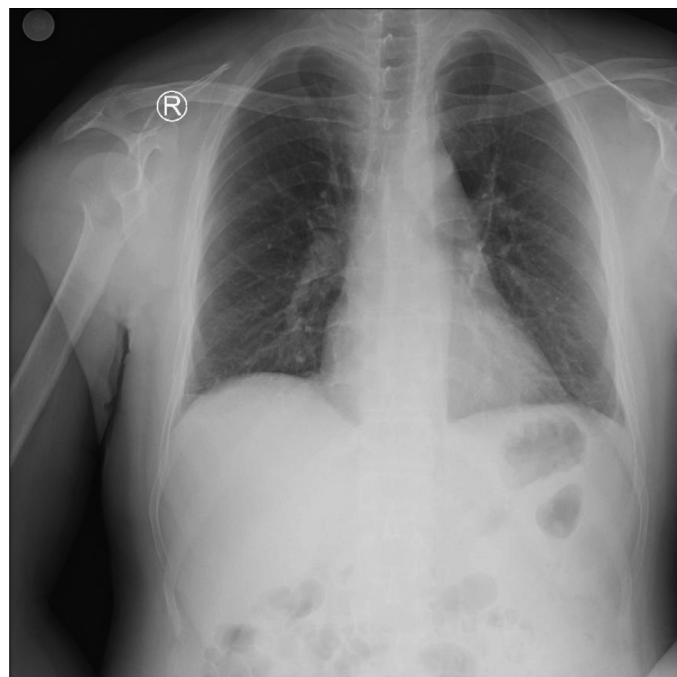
Chest X-ray was evaluated as normal
